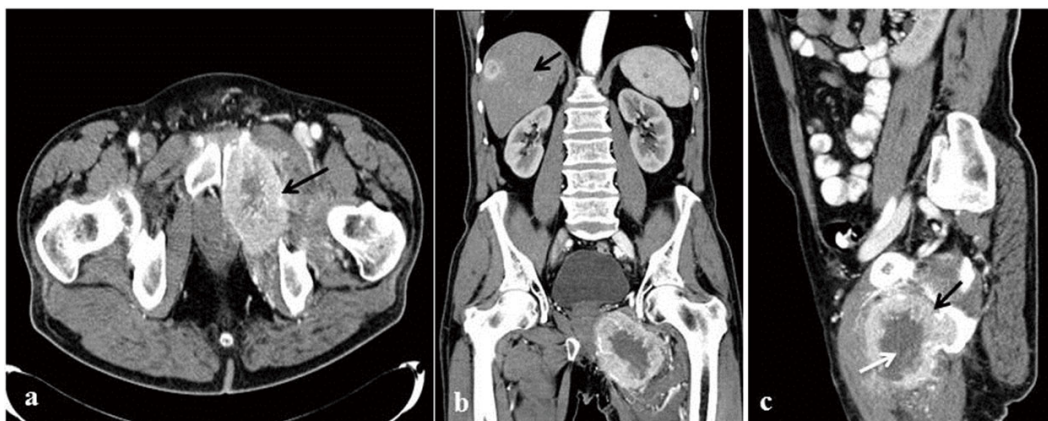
CT imaging. a) axial, c) sagittal, postcontrast image shows PGL metastatic to the os pubis l. sin. (arrow) before treatment with a large osteolytic lesion in the ramus inferior and in the ventral part of the ramus superior of the os pubis l. sin. Tumor infiltrate transverse dimensions are 7.9 cm \times 19.8 cm, vertical dimension is 10.3 cm. Inner part of neoplasm is necrotic (white arrow), peripheral part is highly vascularised with lamellar calcifications on the surface (black arrow). Tumor has spread through foramen obturatum and infiltrates surrounding muscular structures. b) Coronal CT image confirmed presence of metastatic lesions in the right lobe of liver (arrow). On the other images metastases to retroperitoneum and skeleton were found, as follows: 6 cm \times 5 cm lobulated and/or conglomerate mass in or near the pancreas head with possible minimal associated periaortic and/or peripancreatic adenopathy compatible with neoplasm, approximate 8 cm \times 7 cm left ischium lytic lesion with extension into soft tissues compatible with metastasis, and spine and vascular calcification upper thoracic spine foci of uncertain significance.
